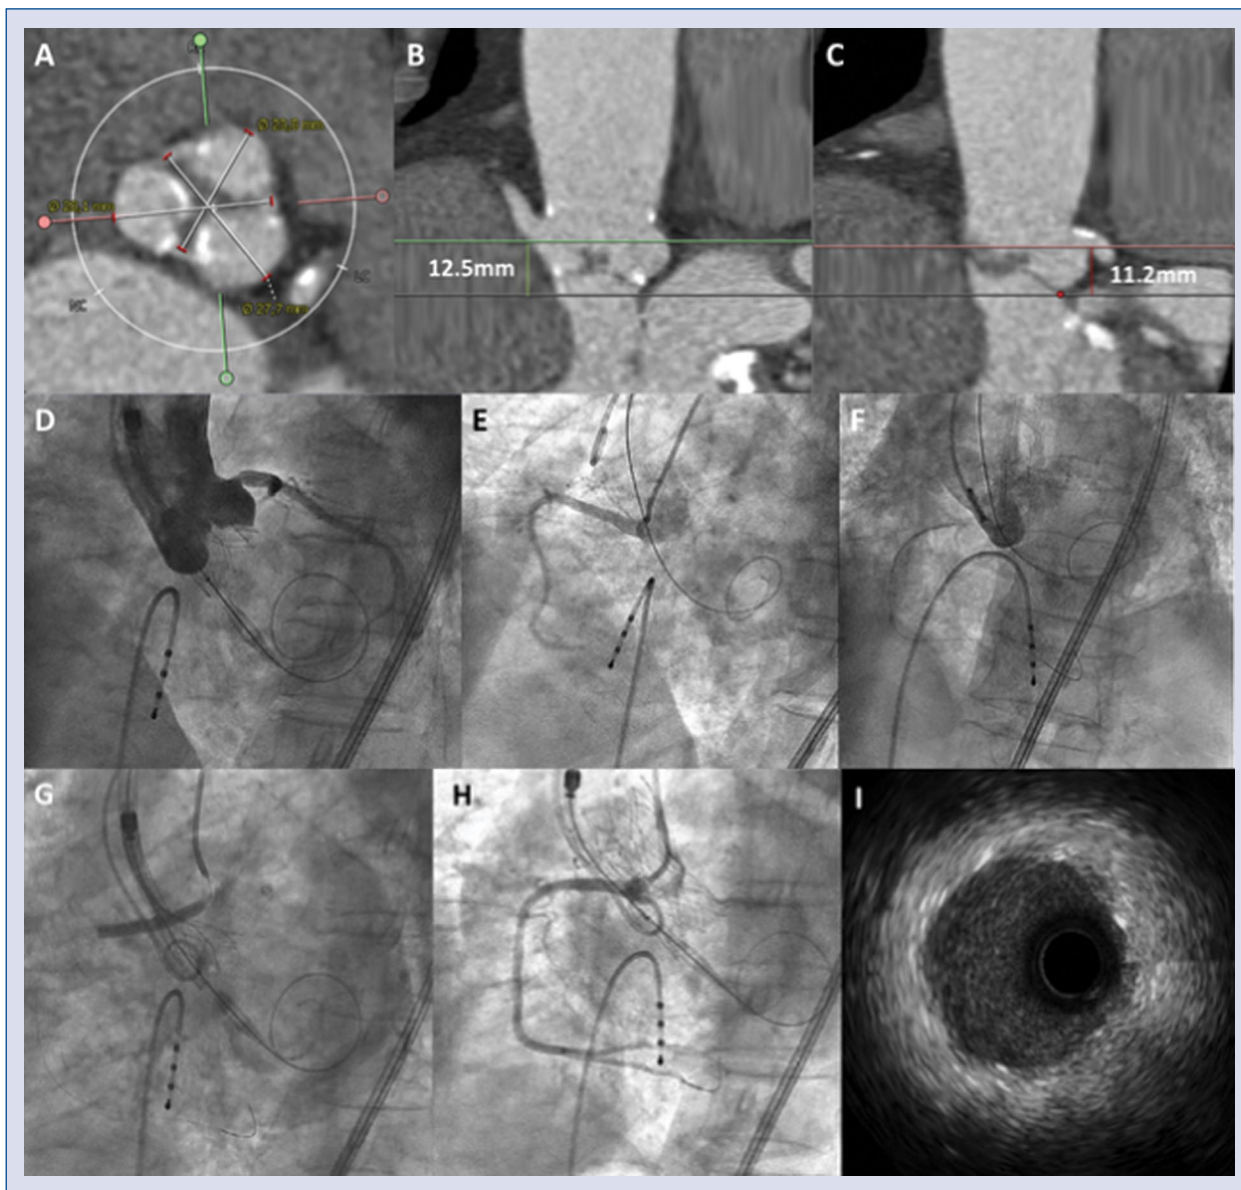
A. Tomographic image at the level of sinuses of Valsalva showing its measurements (left 27.7 mm, right 23.8 mm, noncoronary 28.1 mm); B. Tomographic image showing lack of a clear definition of the origin of the right coronary artery (RCA) within a small right coronary sinus; C. Tomographic image showing a normal origin of the left main coronary artery; D. Angiographic image performed after deployment of the prosthesis showing acute occlusion of the RCA; E. Angiographic image performed after the prosthesis was recaptured showing patency of the RCA; F. Angiographic image showing the guidewire and progress of a stent in the RCA; G. Angiographic image showing the release of the prosthesis and implantation of the stent with the “chimney stent” technique in the RCA; H. Final aortography showing the proper position and expansion of the prosthesis, absence of periprosthetic leak and patency of the RCA; I. Intracoronary imaging using intravascular ultrasound showing correct expansion of the stent implanted in the RCA.
